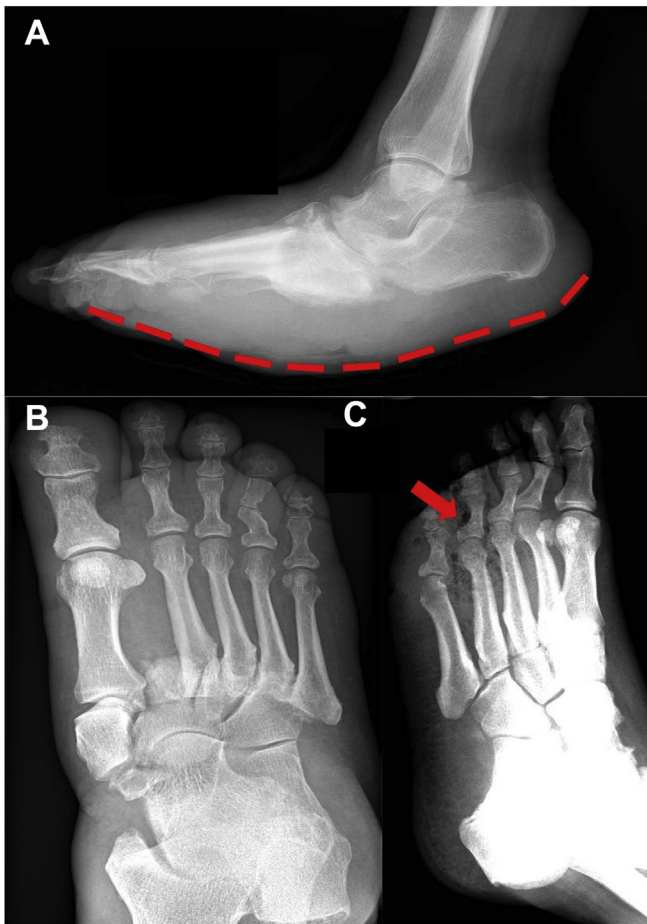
Radiographs of diabetic foot. (a) Lateral radiograph of a Charcot foot rocker-bottom deformity (dotted red line). Note that there is arch collapse and a rotated calcaneum. (b) Radiograph of Charcot foot with Lisfranc fracture dislocation. Note that there is a lateral displacement of the lesser metatarsals with respect to the 1st metatarsal and significant diastasis between the 1st and 2nd metatarsals. There is also a transverse fracture seen at the base of the right 2nd metatarsal. These findings are consistent with a Lisfranc fracture dislocation. (c) Subcutaneous gas seen on a radiograph in a patient with diabetic foot sepsis (red arrow).
